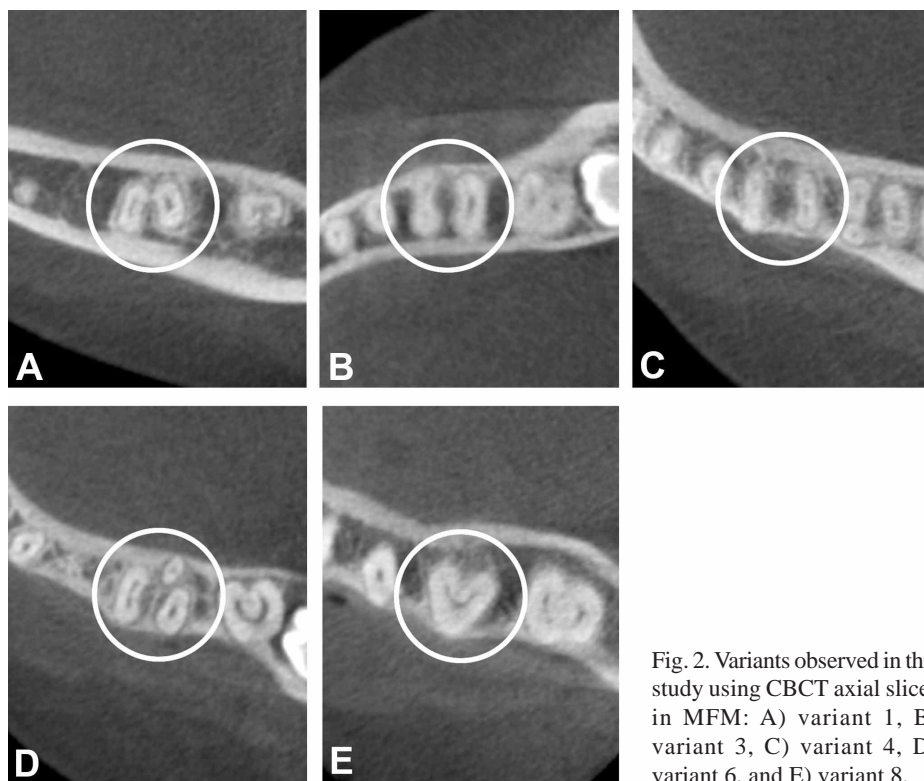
Variants observed in this study using CBCT axial slices in MFM: A) variant 1, B) variant 3, C) variant 4, D) variant 6, and E) variant 8.
